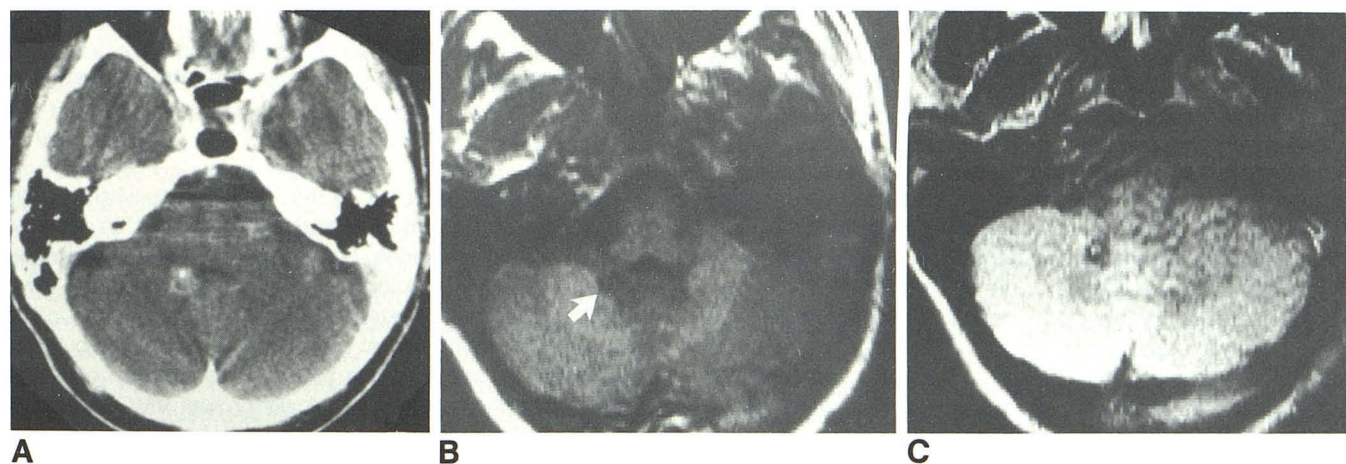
Case 4. A, Contrast-enhanced scan showing mild enhancement of this small, hyperdense lesion. One area of high density and a posterior arc of slightly increased density both suggest opacification of small blood vessels. Plain CT (not shown) showed mixed hyper- and hypodensity without definite calcification. The mass encroaches slightly upon the fourth ventricle. B, MR, 8 months later. IR 1500/450/4 T1-weighted section slightly below the level in A. There is small region of prolonged T1, similar to the T1 of gray matter, projecting
